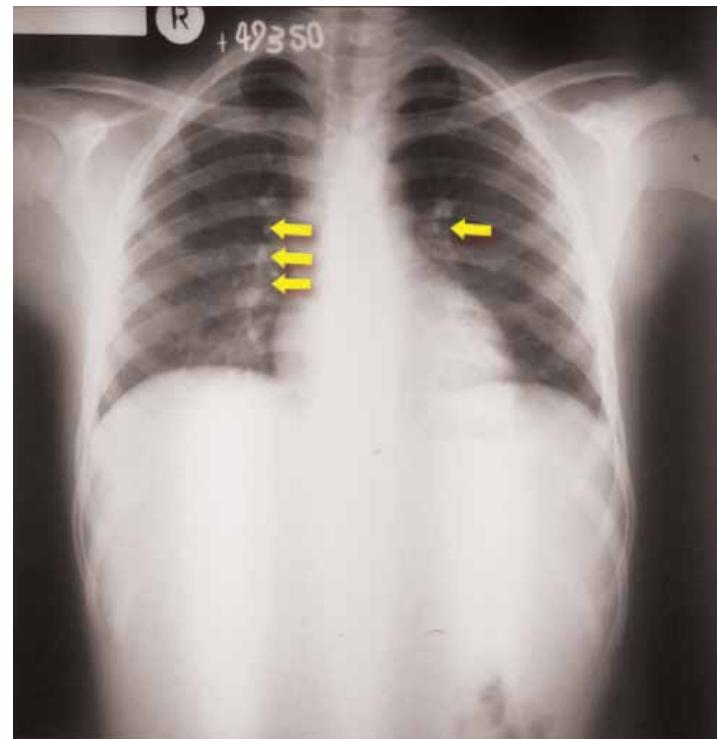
Posterior-anterior chest X-Ray on admission, showing bilateral granuloma and hilar node calcifications (arrows). No alveolar consolidations. (Courtesy of the Corozal Community Hospital, X-ray Department)
